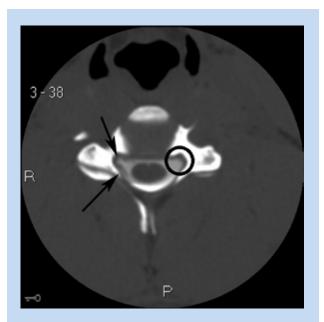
CT myelogram axial view at C5. Nerve roots and rootlets are visualized on the uninvolved side (arrow); no nerve roots are visualized on the involved side (right side of image, circled).
